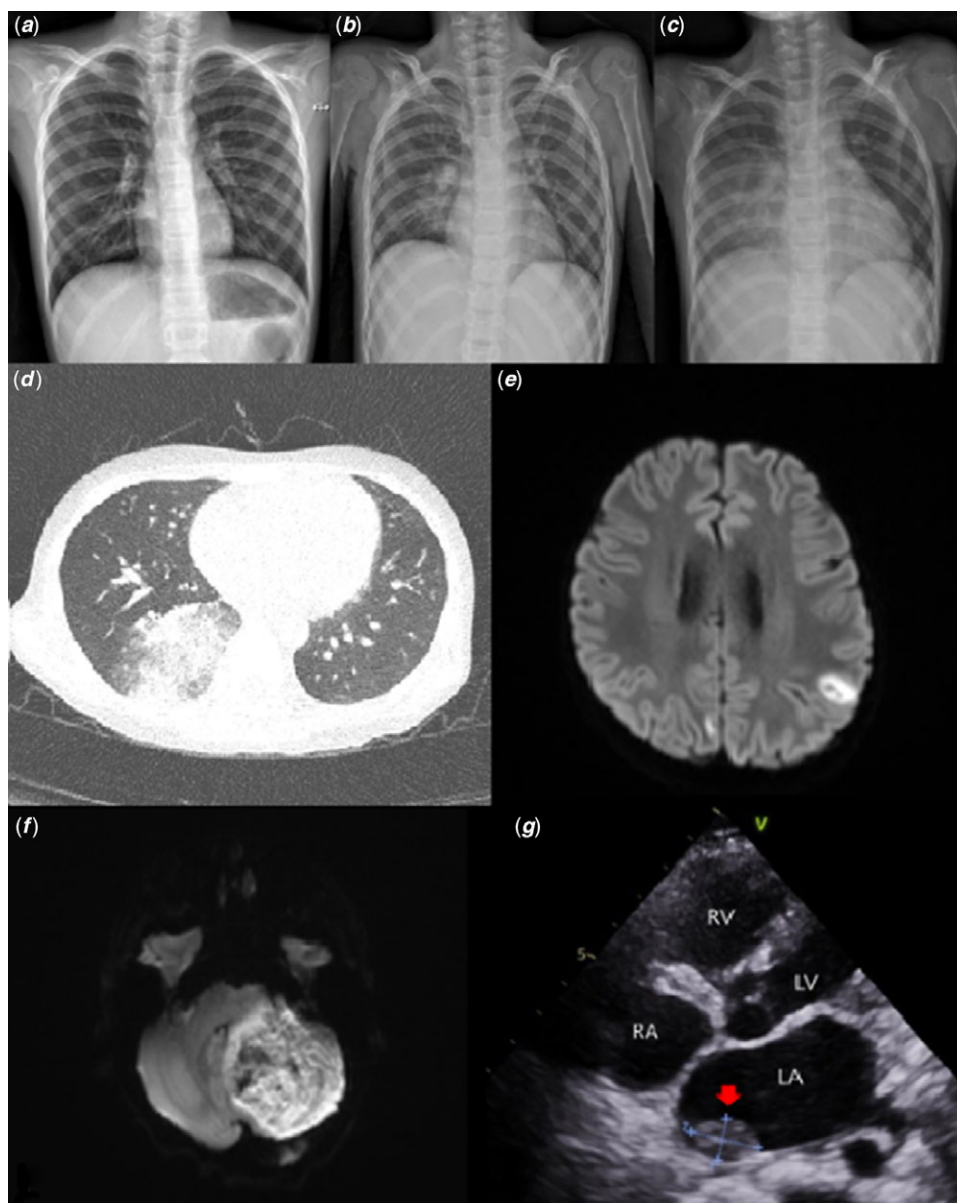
Imaging studies of case 1. (a) On the day of admission, no active lung lesion was found on the chest radiography. (b) On hospital day 3, pulmonary consolidation in the right lower lobe lung was found on the chest radiography. (c) Treatment with antibiotics and the antifungal agent started, but pneumonia worsened on hospital day 4. (d) On the chest CT scan, lobar pneumonia was found in the right lower lobe of the lung. (e and f) On the brain MRI scan, multifocal diffusion restricted lesions with intralésional haemorrhage at both the cerebral hemisphere and left cerebellum were found. (g) On echocardiography, a large thrombus with a size of 20×11.3 mm was identified in the left atrium.
